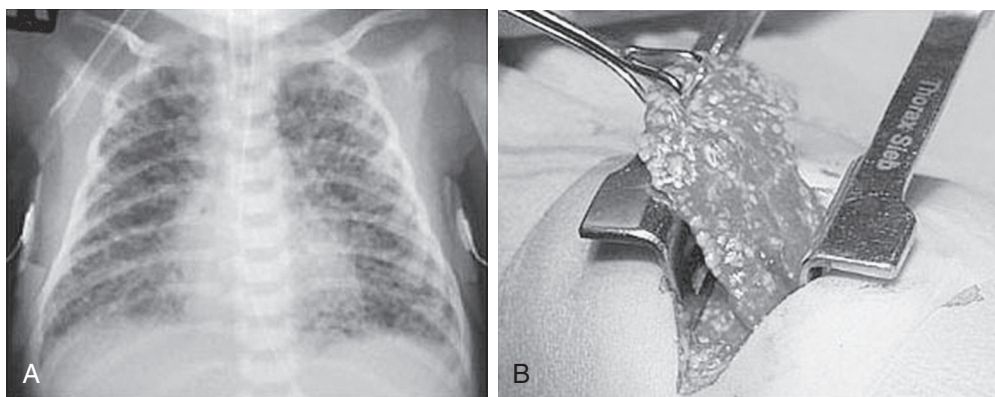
■ Pulmonary lymphangiectasia. A, The chest radiograph demonstrates the bilateral “soap bubble” appearance of lymphangiectasia. B, Gross findings at surgery demonstrated the cystic nature of the disease.
